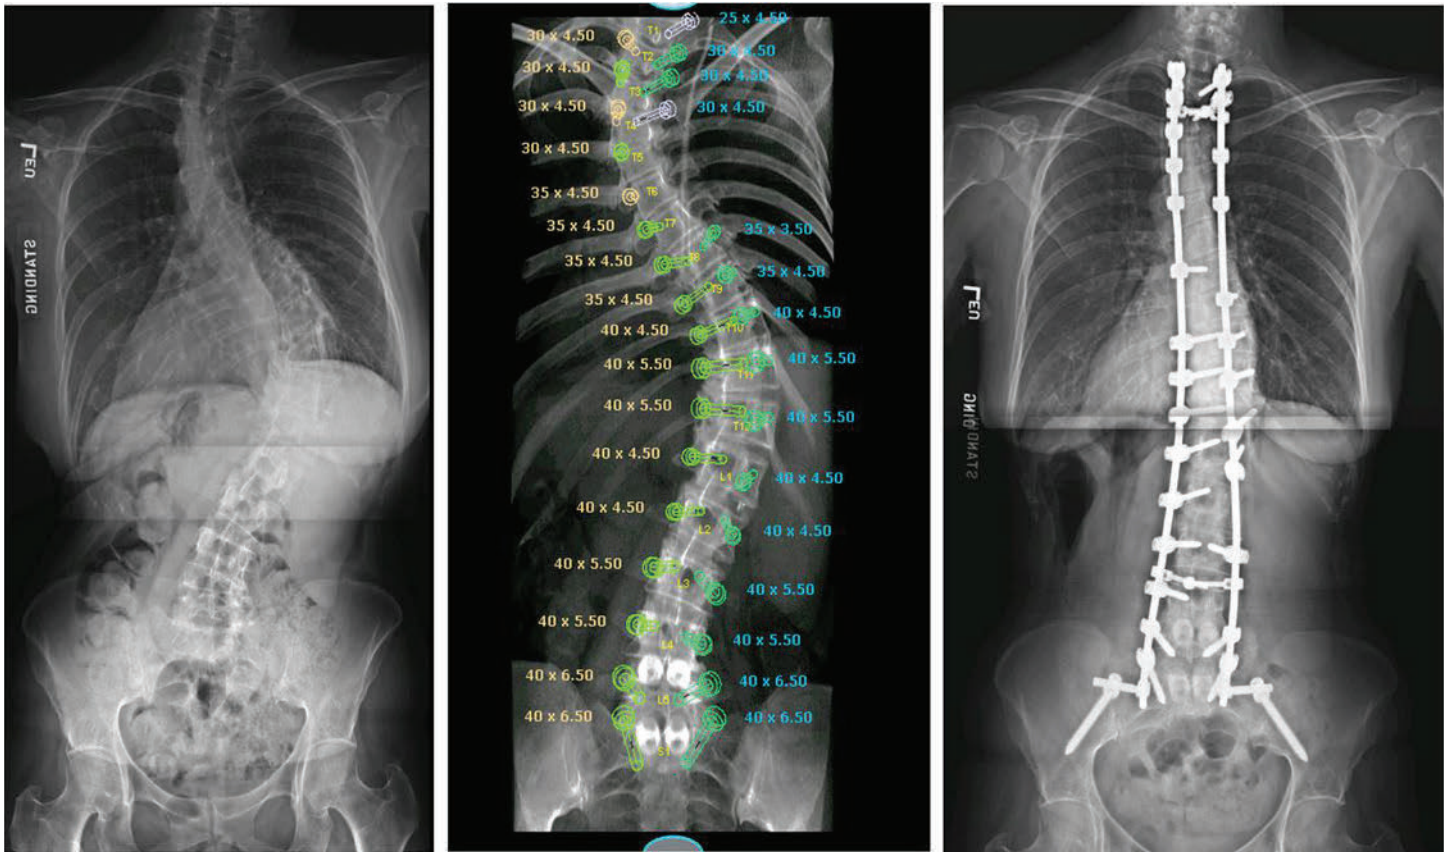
The x-ray on the left shows a patient with large thoracic and lumbar scoliosis which is effecting heart and lung function. . The middle image demonstrates the pre-operative blueprint showing the location where screws will be placed during scoliosis correction surgery. The x-ray on the right shows the final location of the implants after surgical correction.
